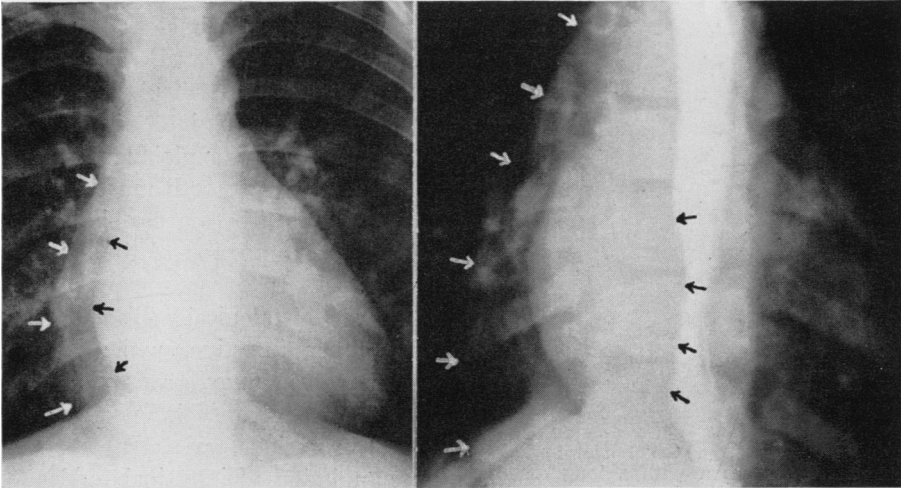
(Case 3.) *Left:* Roentgenogram of the chest, showing mass protruding from the right side of the mediastinum (right border of heart indicated by black arrows. Wall of diverticulum shown by white arrows). *Right:* Heavier roentgenographic exposure, with barium in the esophagus, showing the thoracic mass pressing upon the esophagus (arrows outline borders of the diverticulum).
